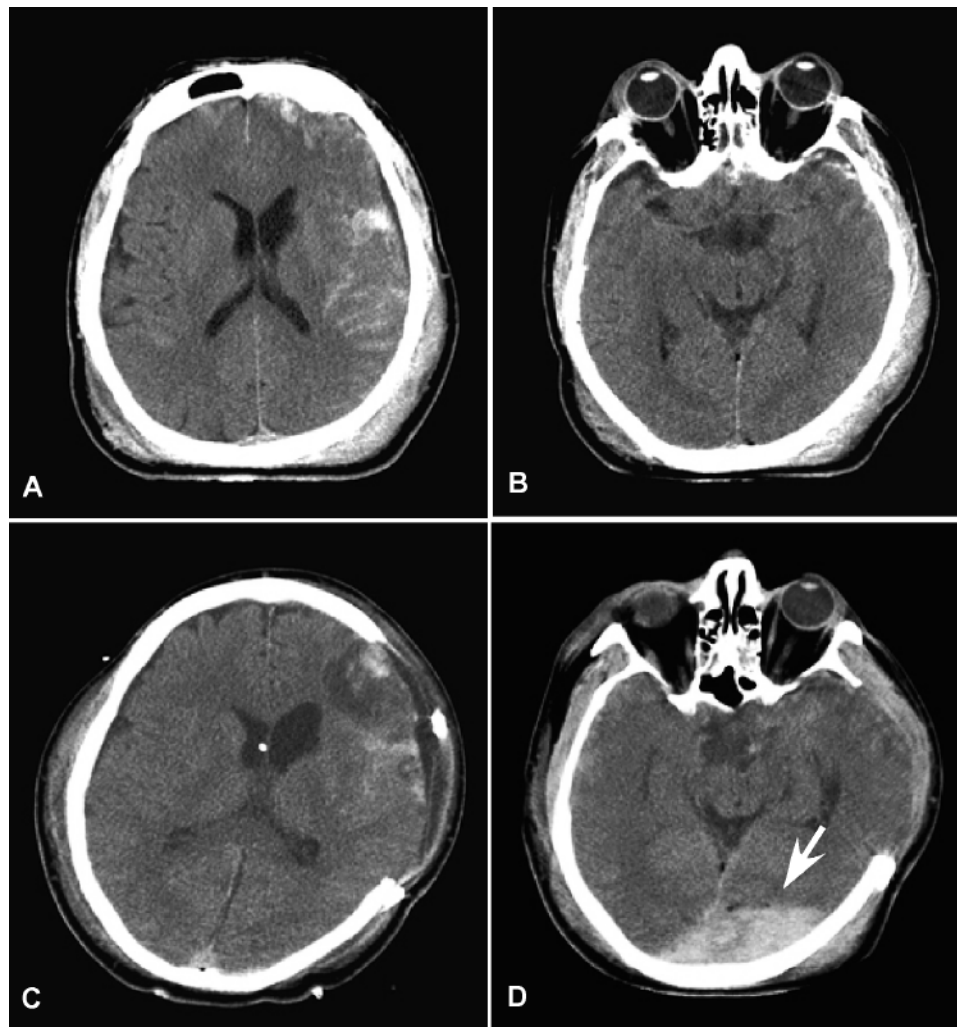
Evolution of remote extraaxial hemorrhage. A and B: Preoperative noncontrast CT scans obtained in a patient with traumatic subarachnoid hemorrhage and a small SDH who underwent decompressive craniectomy. C and D: Postoperative noncontrast CT scans showing evolution of an occipital EDH (arrow), remote from the site of surgery. The patient underwent an occipital craniotomy and evacuation of the EDH. At surgery a linear, nondisplaced skull fracture was found overlying the occipital EDH. A retrospective review of this patient's CT scan suggested that the fracture was parallel to the cuts of the CT image and the density of the occipital bone had masked detection of the fracture on the scout CT image.
